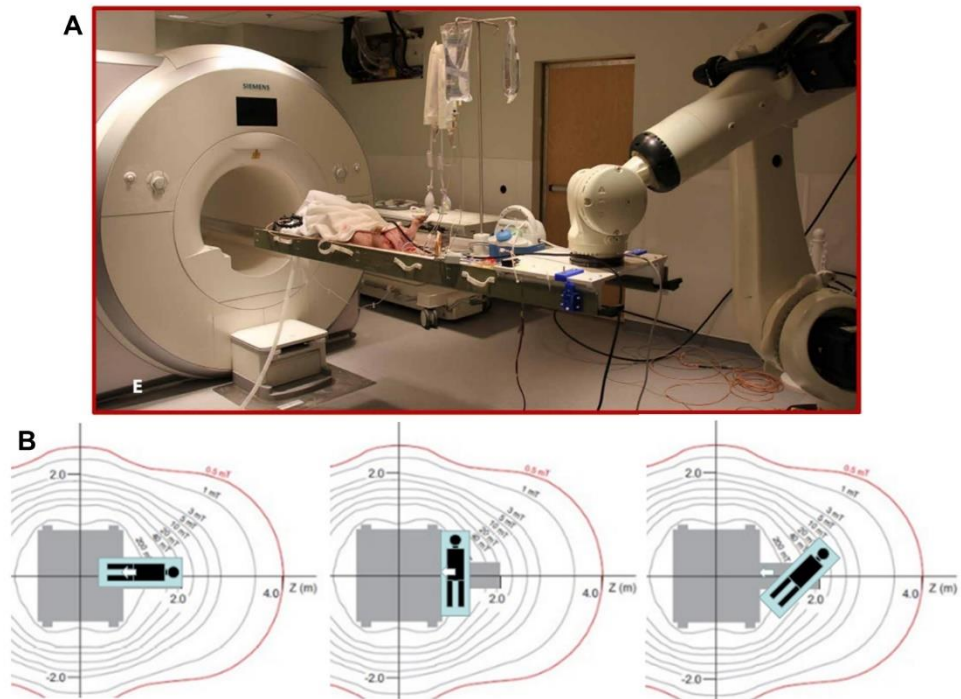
Fringe field navigation (FFN). FFN utilises the magnetic field external to the MRI scanner to navigate magnetic guidewires through narrow vessels for catheterisation. With the patient table attached to a robotic arm (A), the patient can be rotated and moved through the fringe field, allowing the direction of the magnetic field gradient to be aligned with the required axis of actuation (B). Figure adapted from Tremblay *et al.* (2014) and Azizi *et al.* (2019).
